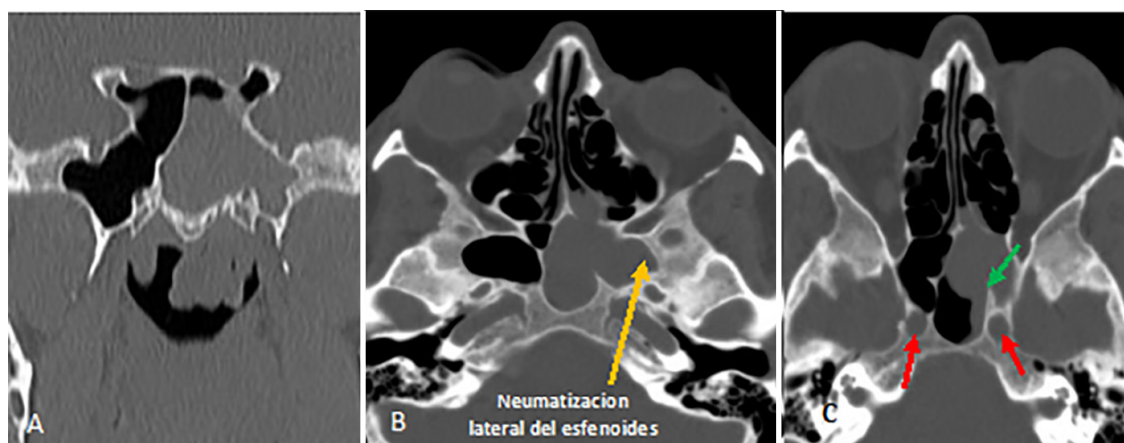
Computed tomography of the facial massif. A: Coronal slice; B and C: Axial slice. The left sphenoid sinus appears occupied by a polypoid extension reaching into the nasopharynx. The sphenoid sinus exhibits lateral pneumatization (yellow arrow), and the protruding carotid arteries are visible within the sinus (red arrows), with a bony septum inserted into the artery (green arrow).
